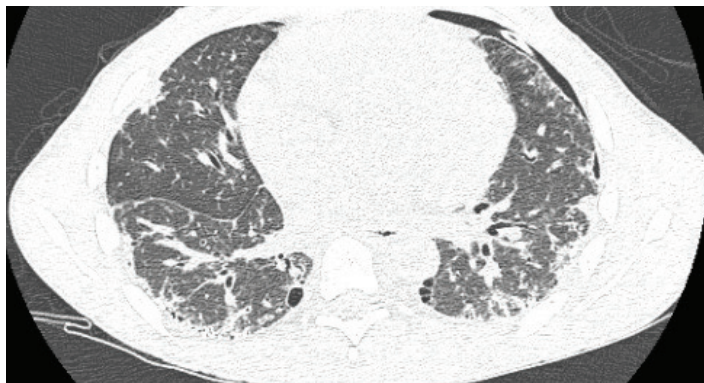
Non-enhanced high-resolution CT scan of thorax demonstrating interstitial lung disease from suspected NSIP, paraseptal emphysema, and left pneumothorax with 8Fr tube.
